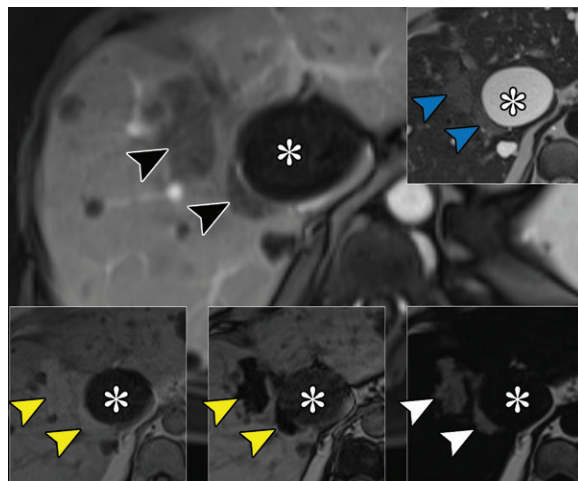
Masslike steatosis mimicking infiltrative malignancy in a 65-year-old woman with necrotizing pancreatitis. Axial T1-weighted portal venous phase MR image shows hypoattenuating “masses” (black arrowheads) with corresponding intermediate hyperintensity at T2-weighted imaging (top right inset, blue arrowheads), which might raise suspicion for malignancy. Opposed-phase chemical shift MR image (middle inset) shows marked hypointensity of these foci (yellow arrowheads) compared with on the in-phase image (left inset), consistent with steatosis. The fat-only Dixon image (right bottom inset) shows focal steatosis with maximal contrast (white arrowheads), as the remainder of the liver, including an adjacent cyst (*), has no signal.
